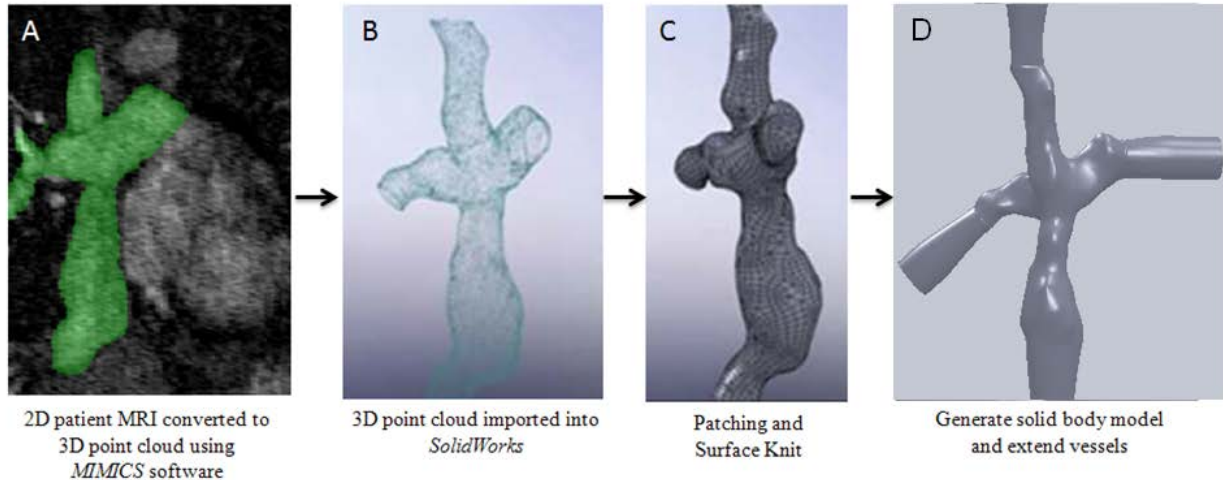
Generation of the Patient-specific TCPC Model. A) 2-D patient MRI converted to 3-D point cloud in MIMICS, B) Smooth point cloud mesh imported into SolidWorks; C) Surface knit to solid body; D) Vascular extensions to the solid body TCPC (derived from<sup>31, 54</sup>).
